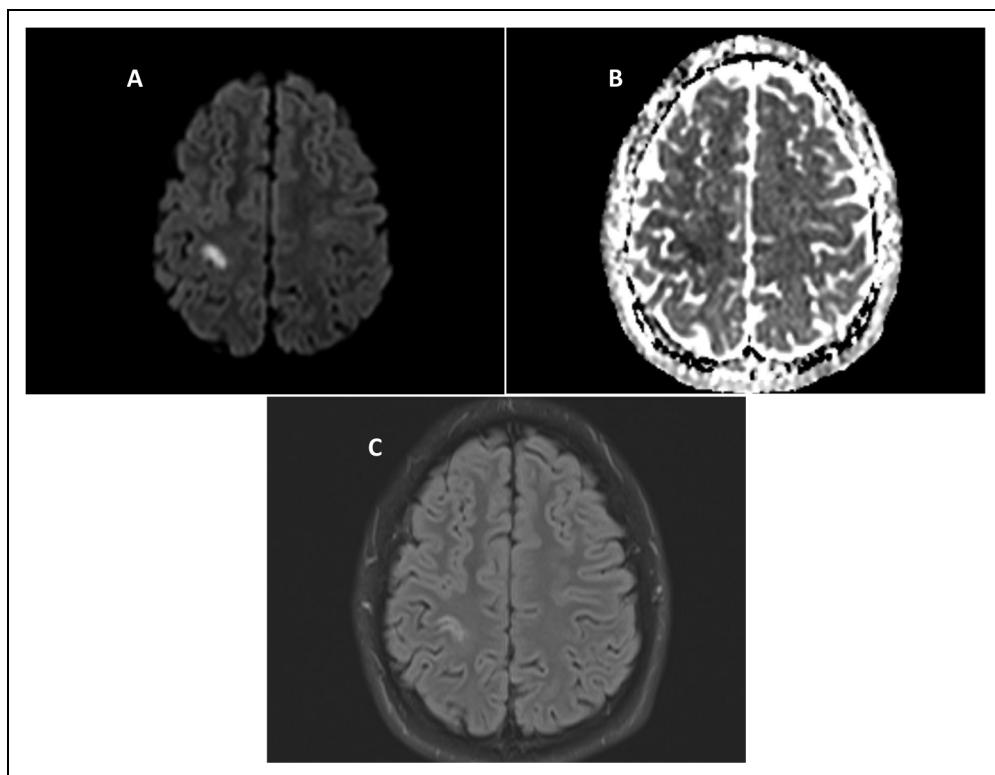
Brain magnetic resonance imaging 3 days post onset of neurological symptoms. (A) Diffusion-weighted imaging; (B) Apparent diffusion coefficient; and (C) Fluid attenuated inversion recovery.
